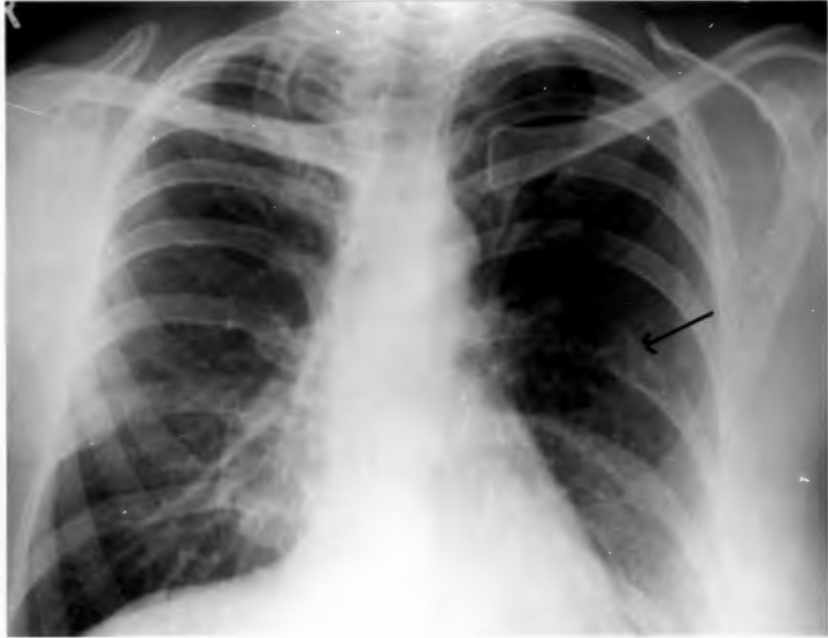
Mrs. E. S. Chest X-ray on 4th January, 1973 shows rib metastases.
